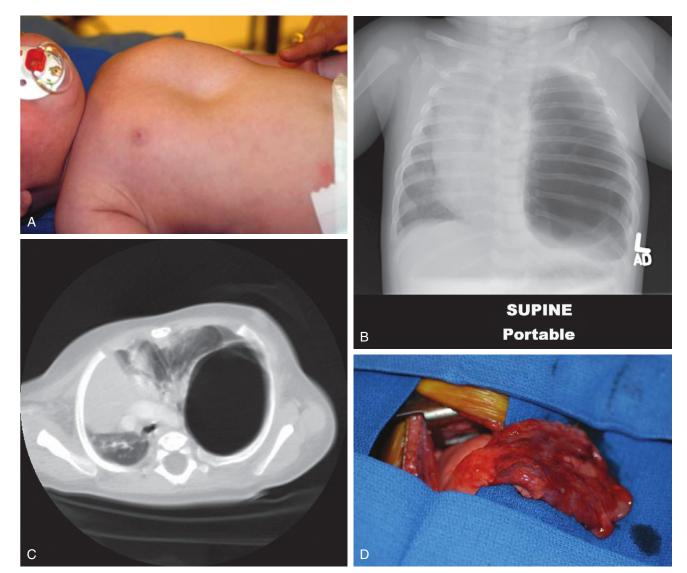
A, Clinical examination of an infant with primary pulmonary blastoma with thoracic asymmetry and hyperinflation. B, Anteroposterior chest radiograph demonstrating the unilateral hyperinflation of the left lung and mediastinal shift to the right. C, CT scan of the chest showing the pulmonary hyperinflation and tumor mass. D, Intraoperative tumor.
